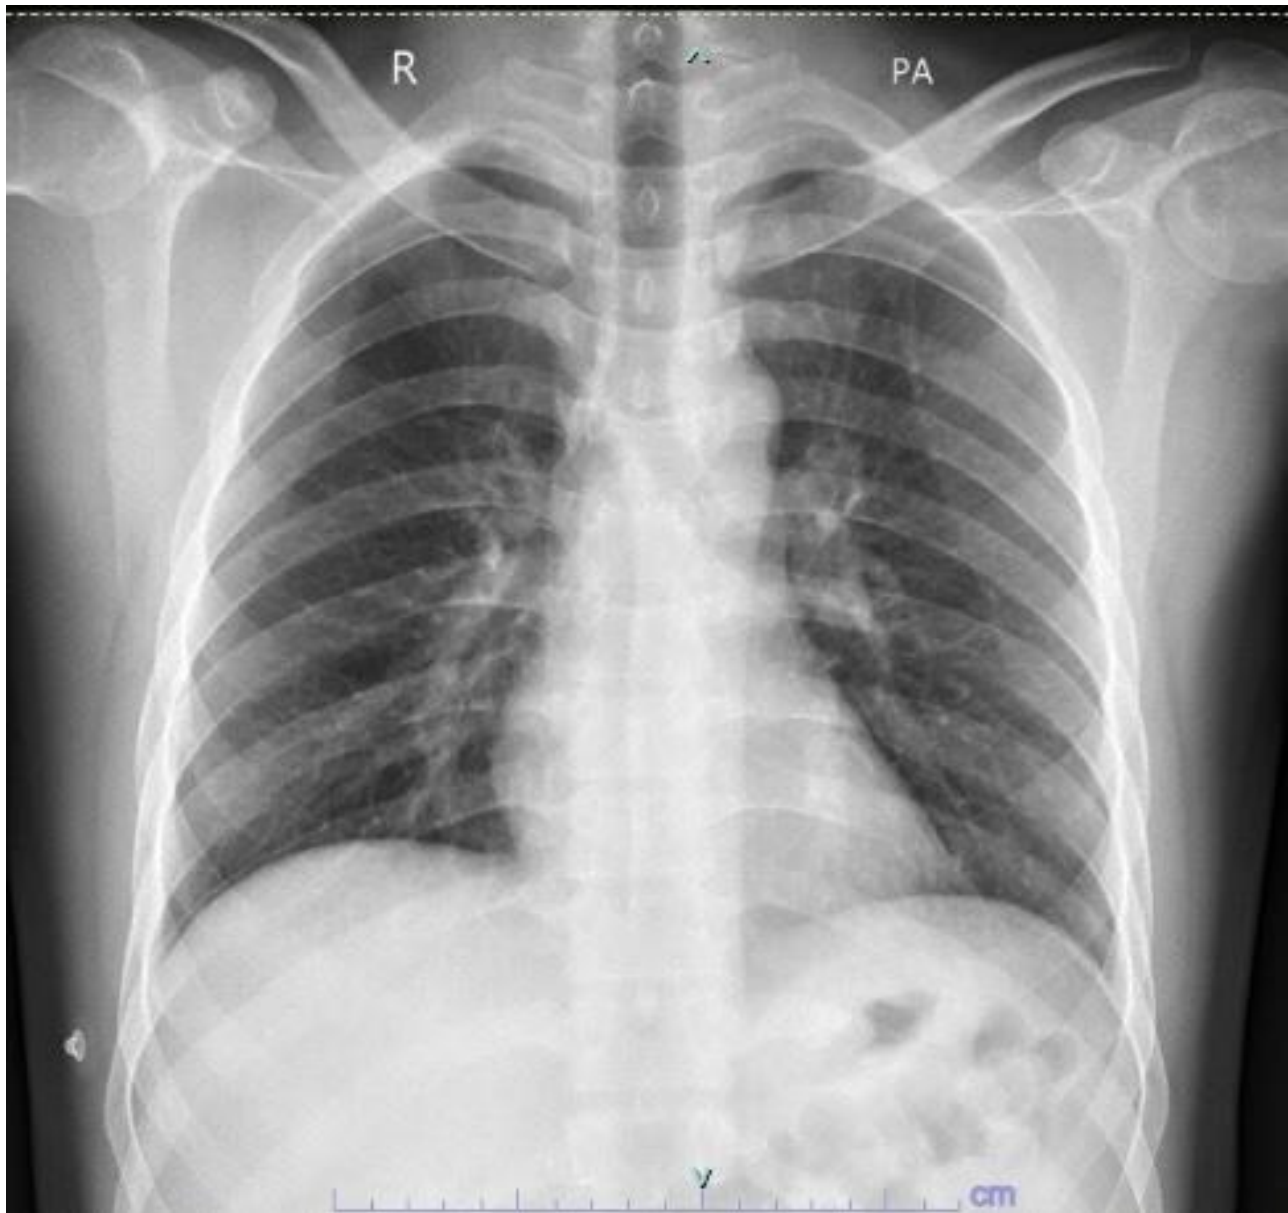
Chest X-ray demonstrating clear lung fields and intact diaphragmatic contour.
